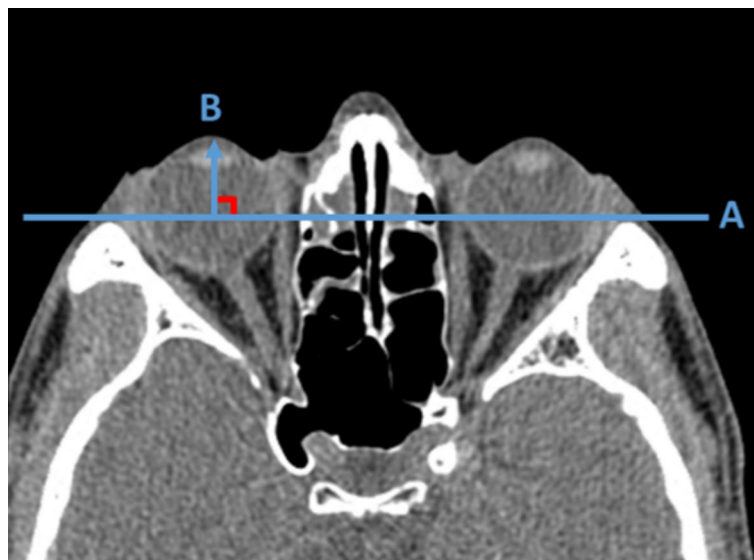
Manual measurements of proptosis degree using computed tomography (CT) images. A line is drawn between the lateral orbital rims on the axial plane that bisects the lens. Then, Line B is drawn perpendicular to Line A, extending towards the posterior surface of the cornea to measure proptosis.
